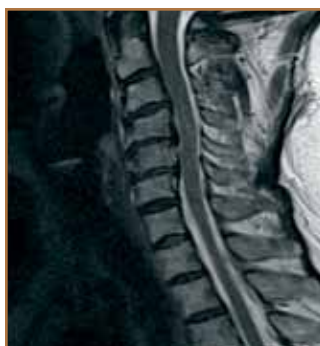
Sagittal T₂-weighted magnetic resonance imaging shows cervical spine of 51-year-old woman who presented with neck and shoulder pain. Multilevel disk degeneration was noted at C4–C5 and C5–C6 levels.
